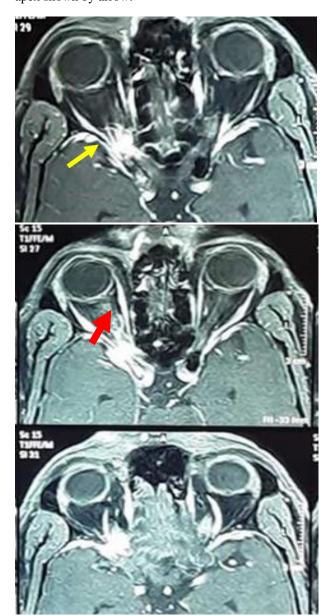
MRI brain: Yellow arrow indicating asymmetrical contrast enhancement on right sided
